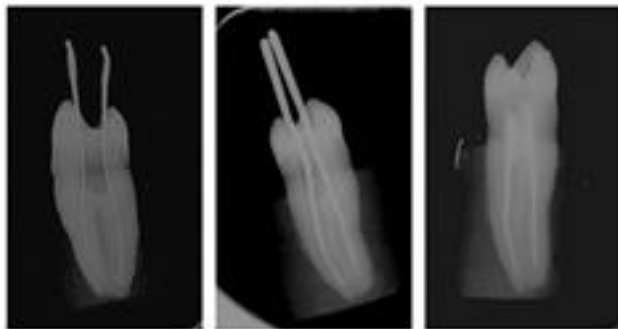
Intraoral Periapical Radiographs Of Endodontic Treatment
